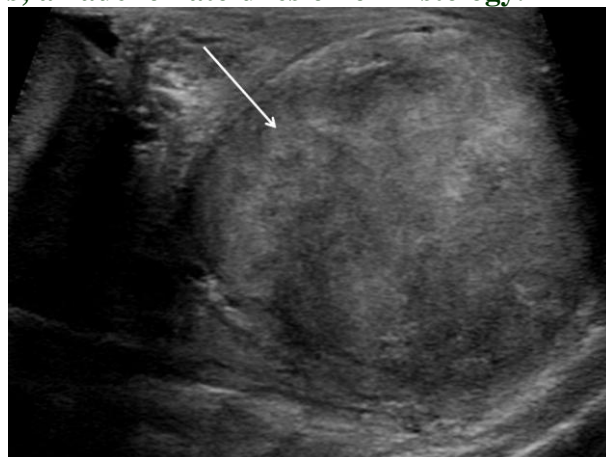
Cavernous Haemangioma of the Spermatic Cord. A well circumscribed lesion of the spermatic cord containing pockets of increased colour Doppler flow (long arrow); a cavernous haemangioma
